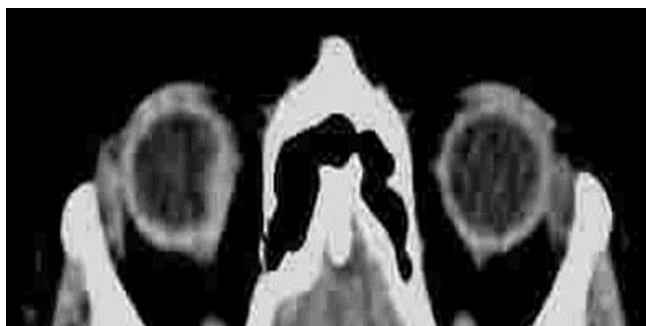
Patient A., 71 years old. Computed tomography fragment. A heterogeneous structure formation measuring 11x3 mm is visualized medially to the right eyelid
